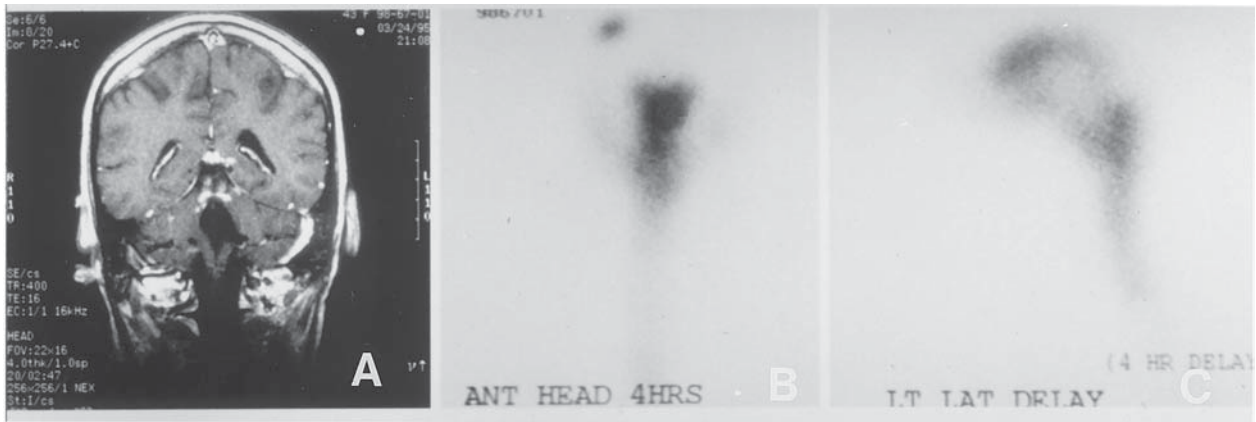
(A) T1-weighted MR scan with gadolinium enhancement reveals abnormal enhancement surrounding a surgical cavity. This woman with breast cancer developed leptomeningeal metastases following resection of a cerebellar metastasis. (B) Anteroposterior and (C) lateral ^{111}In -DTPA radionuclide scans performed 4 h after Ommaya reservoir injection revealed a partial CSF flow block at the level of the foramen magnum.
